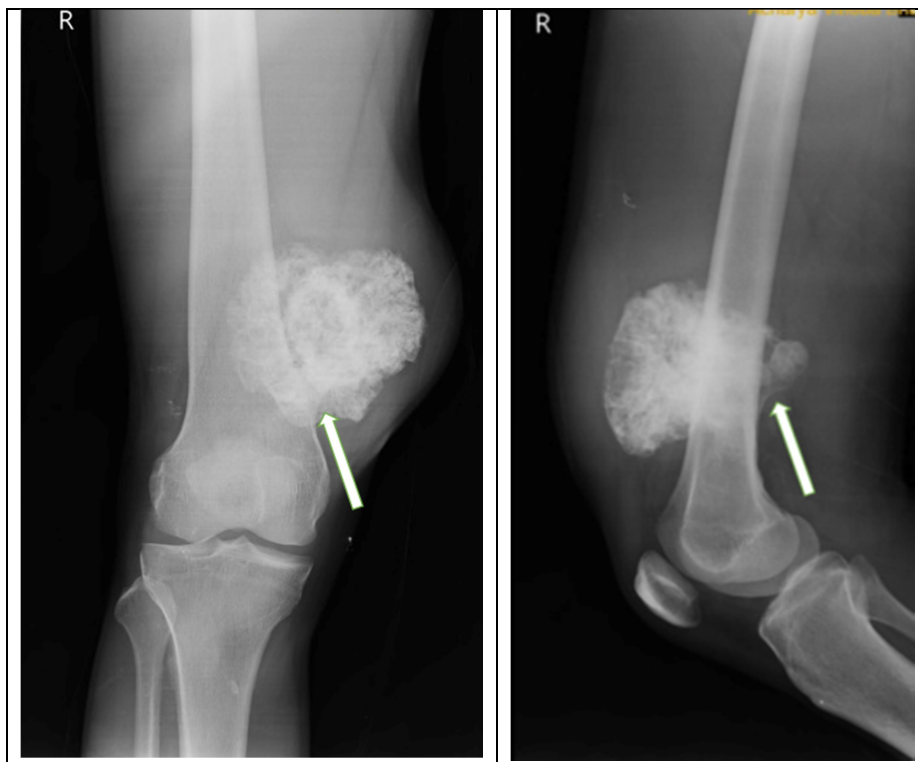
Plain radiograph of the tumour with pedunculated stalk
